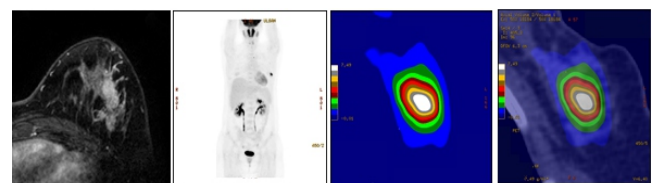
Representative case of a 34 years old patient with left breast cancer. Breast MRI (2min dynamic image) (A), Maximum intensity projection (MIP) image of ^{18}F -FDG PET/CT (B), trans-axial PET image using the 10-step color scale (C), trans-axial fused PET/CT image using the 10-step color scale (D). Pathologic tumor size was 25.0mm, while tumor size on MRI was 50.6mm (A). In PET/CT images, peri-tumoral halo layer (PHL) was designated as the olive-green color layer (20%-30% of SUVmax) and tumor margin was defined as the inner margin of PHL (white arrow) (C, D). The tumor size on PET was 20.7mm, which was substantially closer to the pathologic tumor size than the tumor size estimated by MRI.
